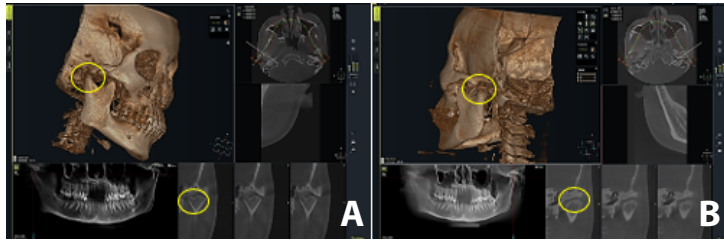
CBCT examination, A. Right and B. Left
